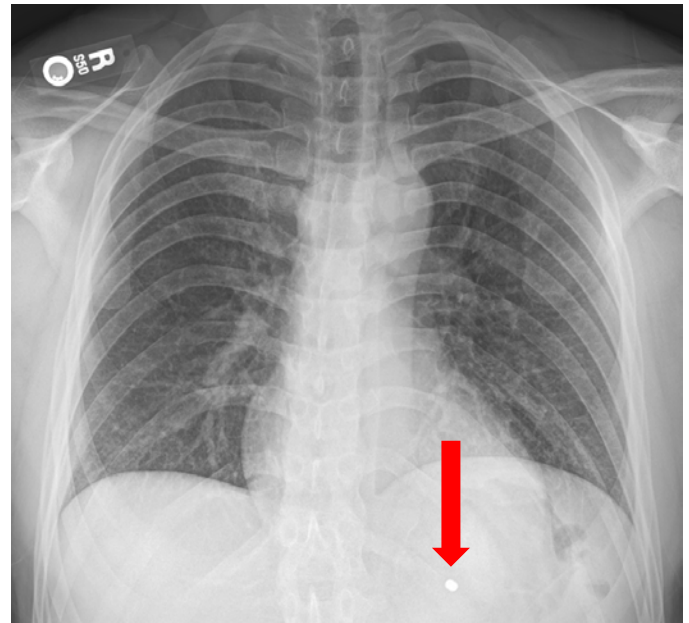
Admission Chest x-ray with radiopaque density
